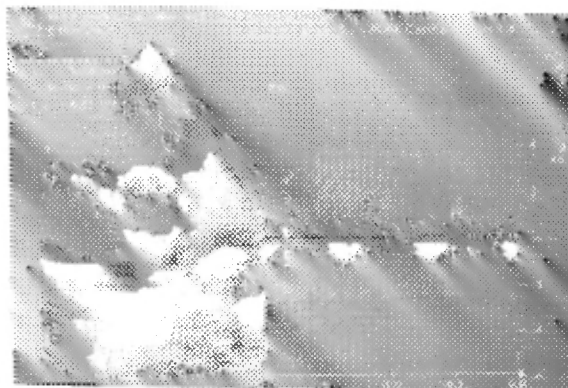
CWF Doppler echocardiographic parasternal short axis view showing pulmonary regurgitation with a maximum velocity of 2.55 m/s with recorded pressure gradient of 26.06 mm Hg giving rise to an estimated diastolic pulmonary artery pressure of 36.06 mm Hg.
